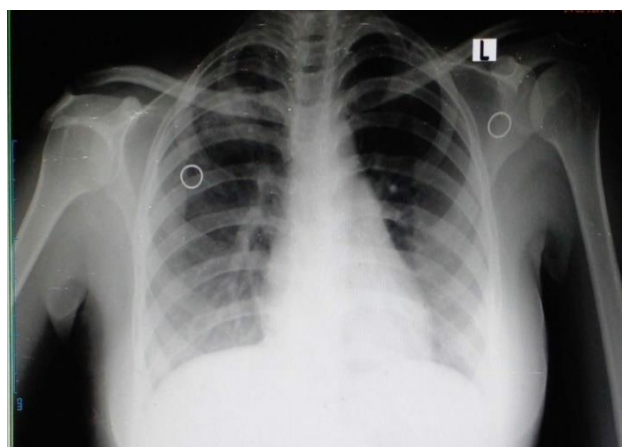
Chest x-ray PA view 1 year ago (at the time of diagnosis of PTB based on sputum.
